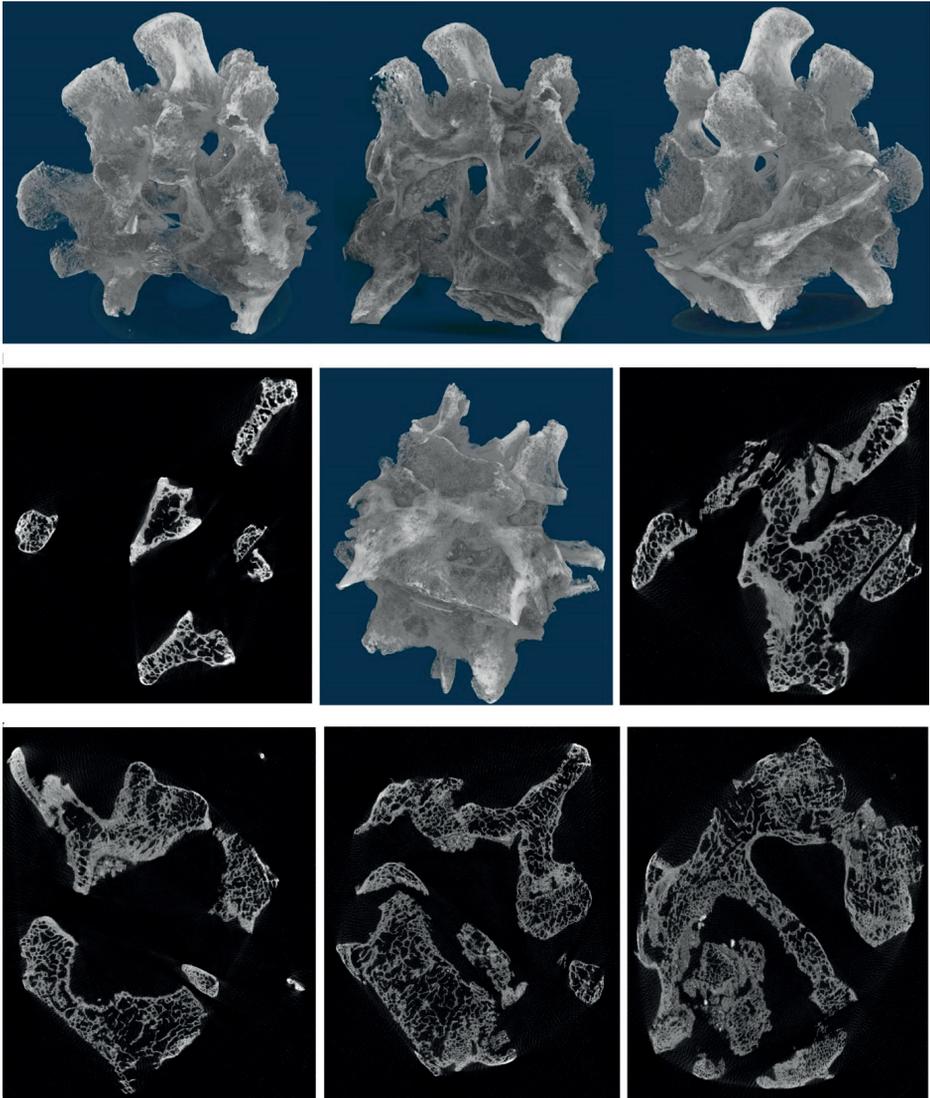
Computed tomography of the fused vertebrae
